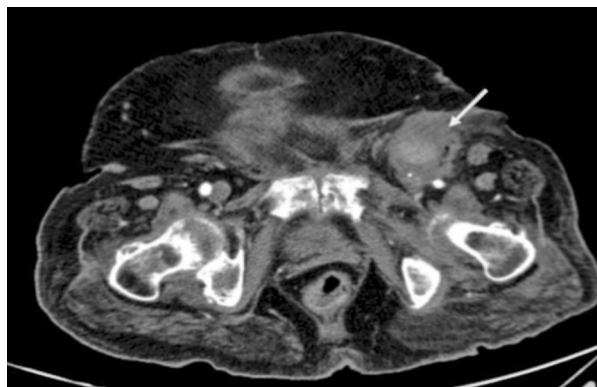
CTA Revealing Left-CFA Infected Pseudoaneurysm (Arrow)
